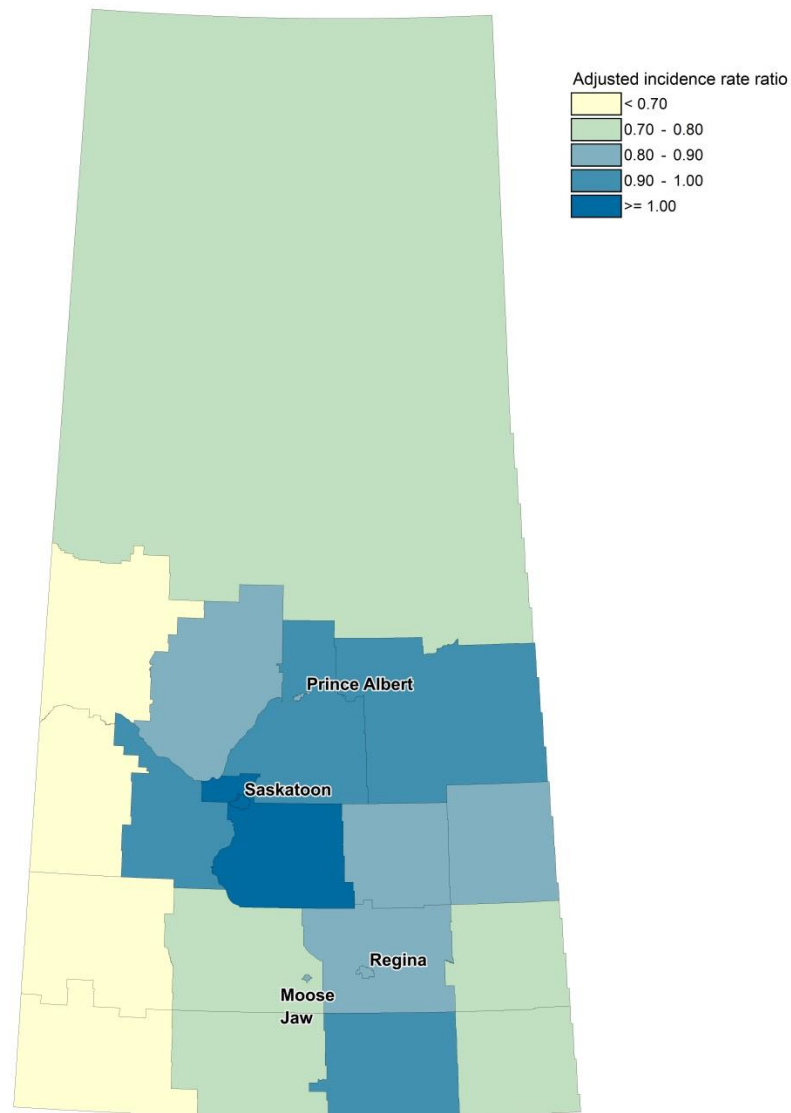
Choropleth map indicating adjusted incidence rate ratios of non-obstetrical ultrasound imaging utilization by census division in Saskatchewan. All 18 census divisions are outlined in grey, and all medium and large population centres (Saskatoon, Regina, Prince Albert, and Moose Jaw) are labeled. The reference category is Saskatoon, the largest population centre in the province. Incidence rate ratios were adjusted for sex, age, First Nations status, Charlson Comorbidity Index, and neighbourhood income quintile. Adjusted incidence rate ratios greater than 1 indicate higher rates of non-obstetrical ultrasound utilization relative to Saskatoon, and adjusted incidence rate ratios less than 1 indicate lower rates of utilization. Comparing Figures 5.1 and 5.2, areas which are more geographically remote generally have lower rates of non-obstetrical ultrasound utilization, and areas which are less geographically remote (surrounding medium and large population centres) generally have higher rates of non-obstetrical ultrasound utilization.
